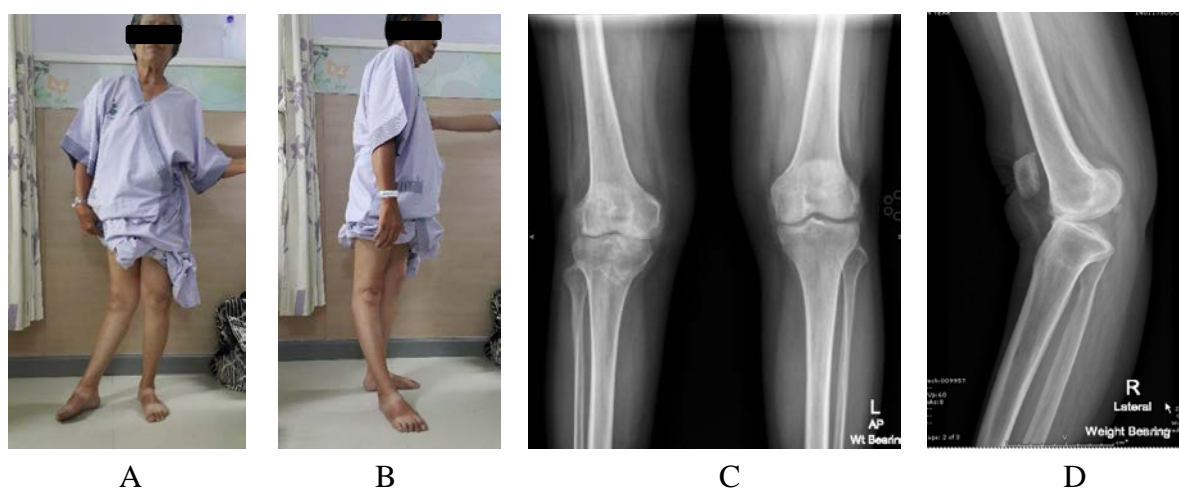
Pre-operative clinical and radiographic evaluation. Picture on left (A, B) show genu valgus and recurvatum deformity. Plain radiograph on the right (C, D) show arthritis change with 42 degrees recurvatum deformity.
